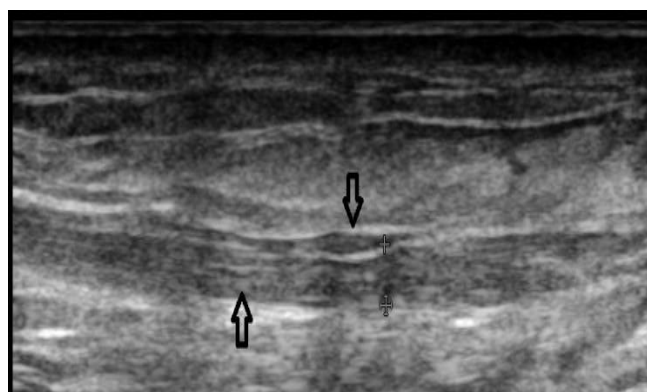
High resolution sonography image of normal median nerve: longitudinal scan in the forearm showing several parallel hyperechoic lines (arrow) in a linear pattern appearing as bundles of straw within two bold echogenic lines, which represent the epineurium.
